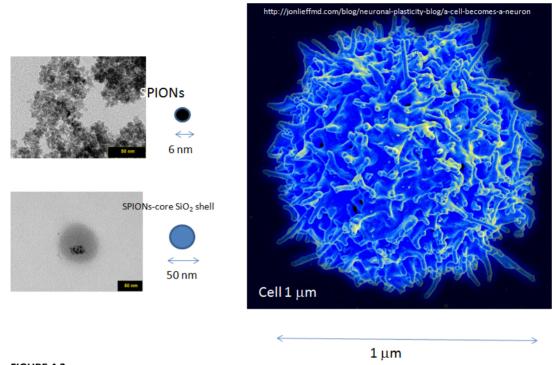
Silica coated SPIONs to be used *in vivo* as negative contrast agents in magnetic resonance imaging (MRI). Adapted from [15]
